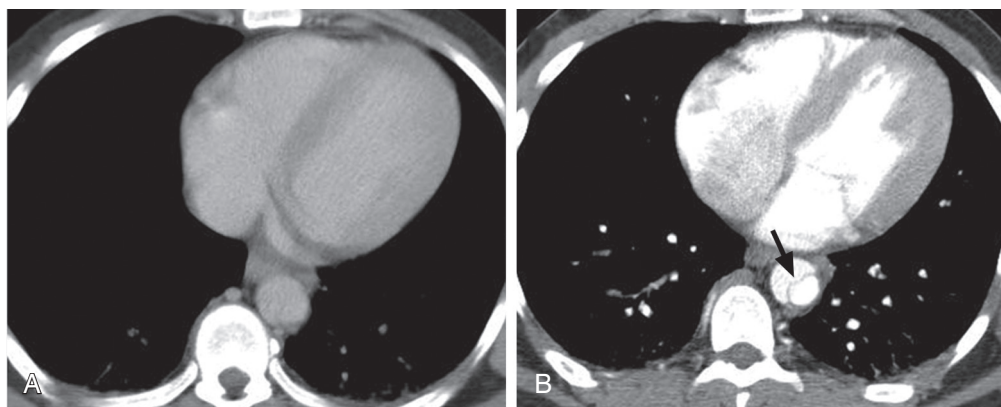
FIGURE e57-9 CT scan of type B aortic dissection. A, Non-contrast-enhanced CT fails to identify the dissection or intimal flap. B, Contrast-enhanced CT identifies the intimal flap (arrow).
